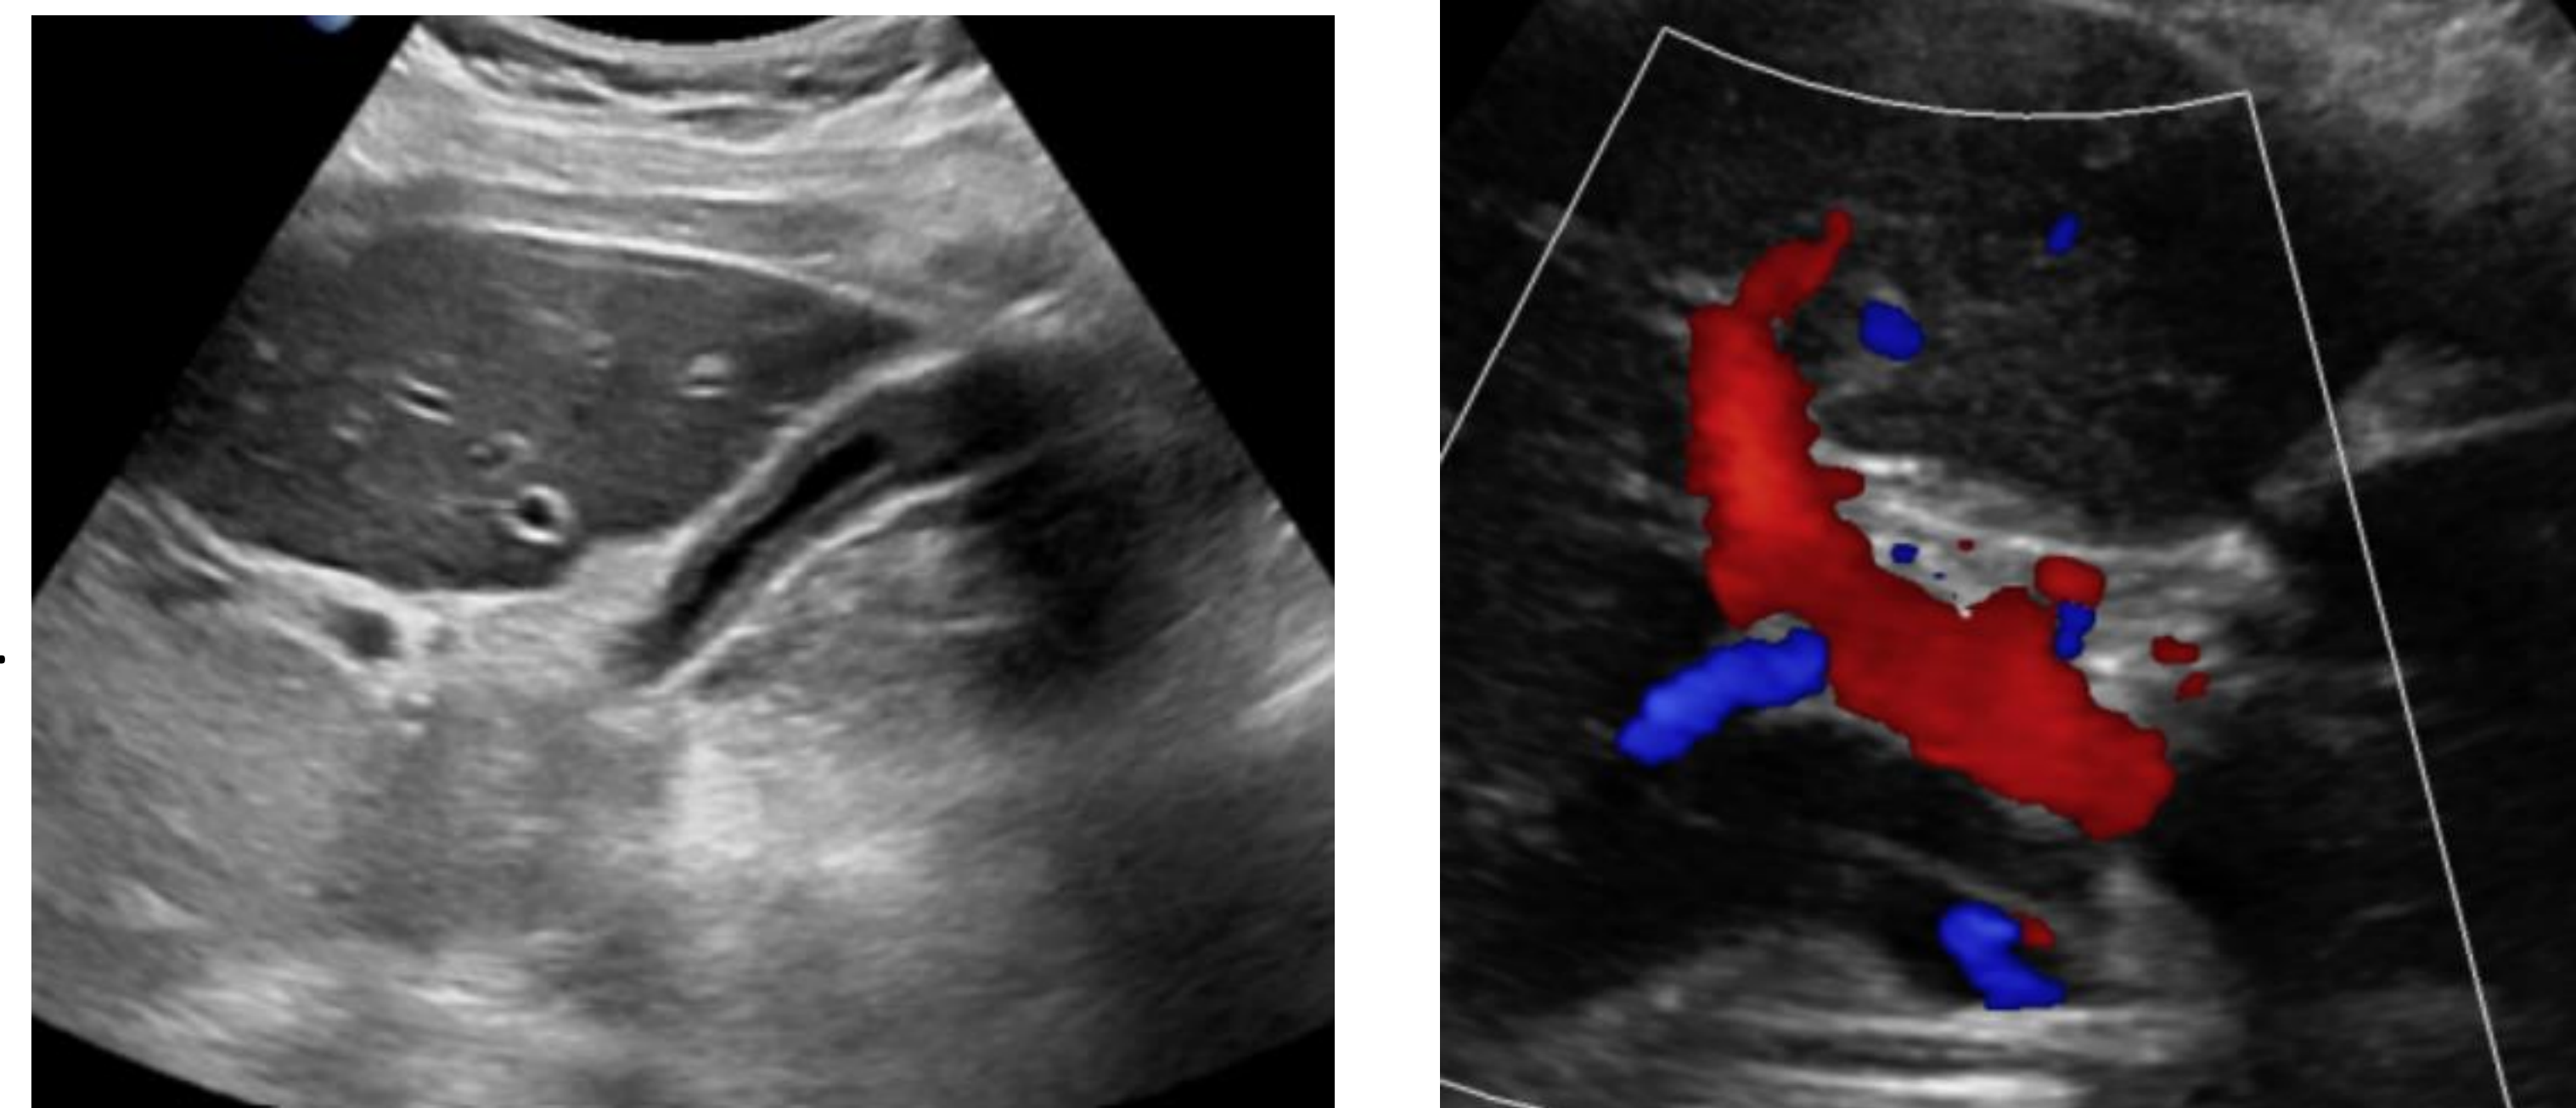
Ultrasound images. Periportal hyperechogenicity can be seen with acute hepatitis (left). No common bile duct dilatation. Patent portal vein (right)
